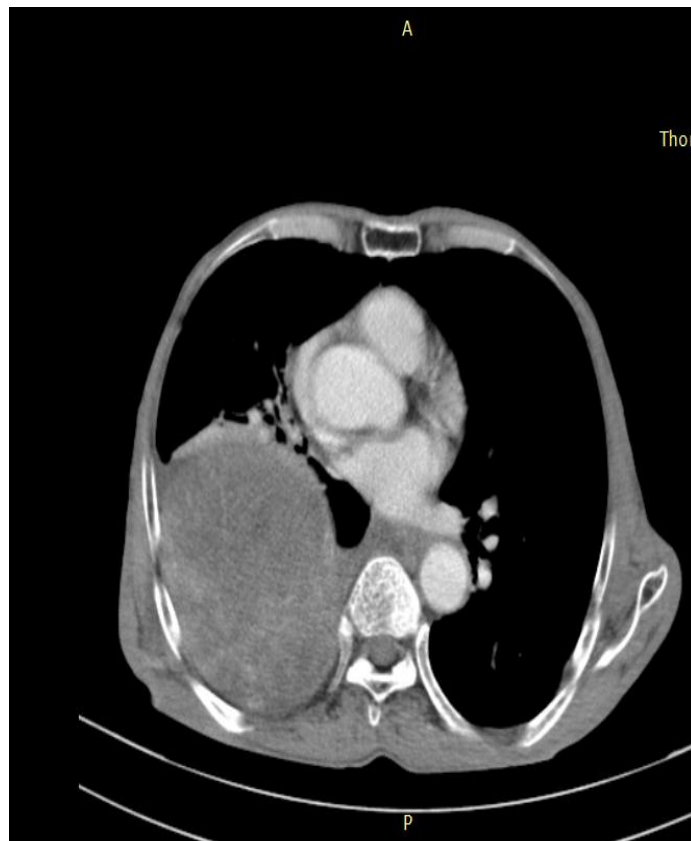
Post contrast axial CT image showing moderate heterogenous post contrast enhancement of the mass. The extrapleural fat is visualised which is seen posterior to the mass.
